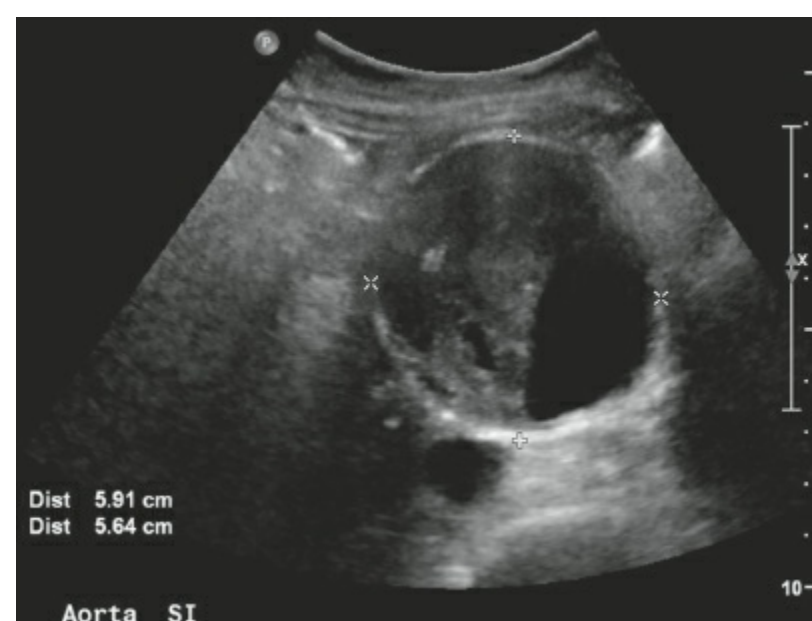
Ultrasound image of a 5.9-cm infrarenal abdominal aortic aneurysm with acentric intraluminal thrombus.
